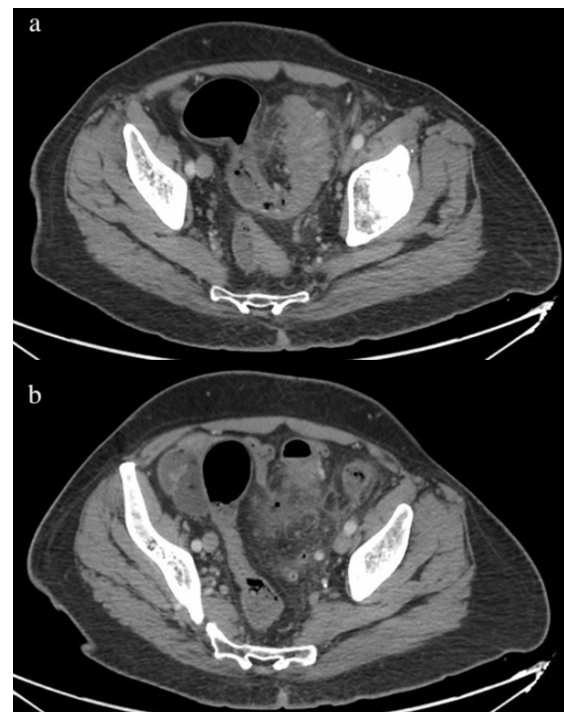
Computed Tomography Scan of the abdomen showing a circumferential short segment wall thickening of the sigmoid colon with multiple diverticular pouches and significant surrounding fat stranding
